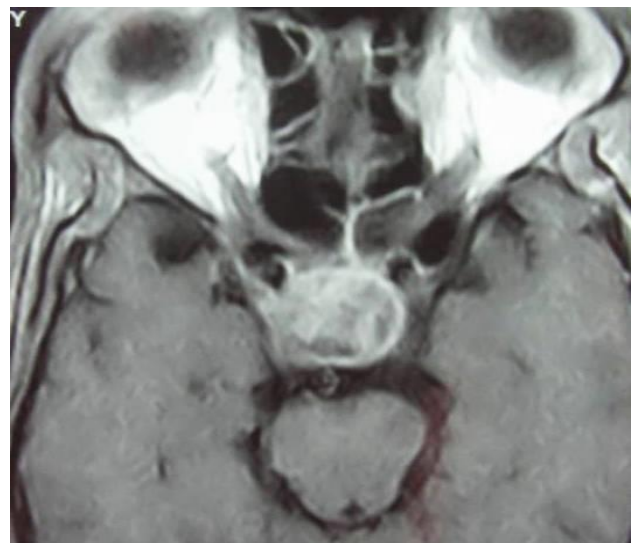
MRI brain showing sellar mass.
